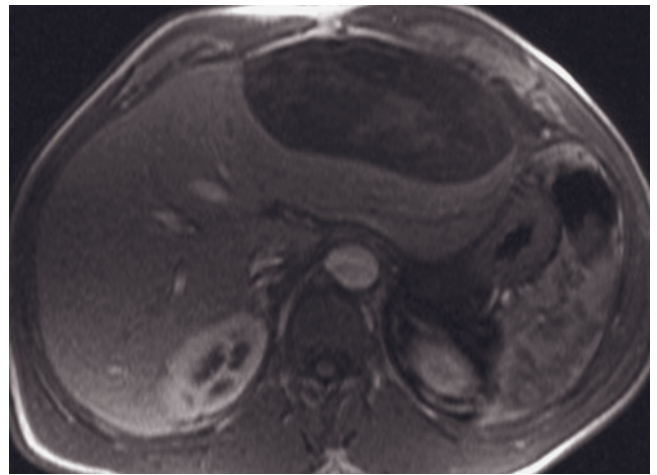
(Continued) image (a) and central mild low signal and peripheral ring of high signal on T1-weighted precontrast image (b), which is diagnostic for subacute hematomas. These lesions do not enhance after gadolinium administration (c), but note that the methemoglobin ring remains hyperintense. A high-signal-intensity laceration tract is also noted (arrow, b).
